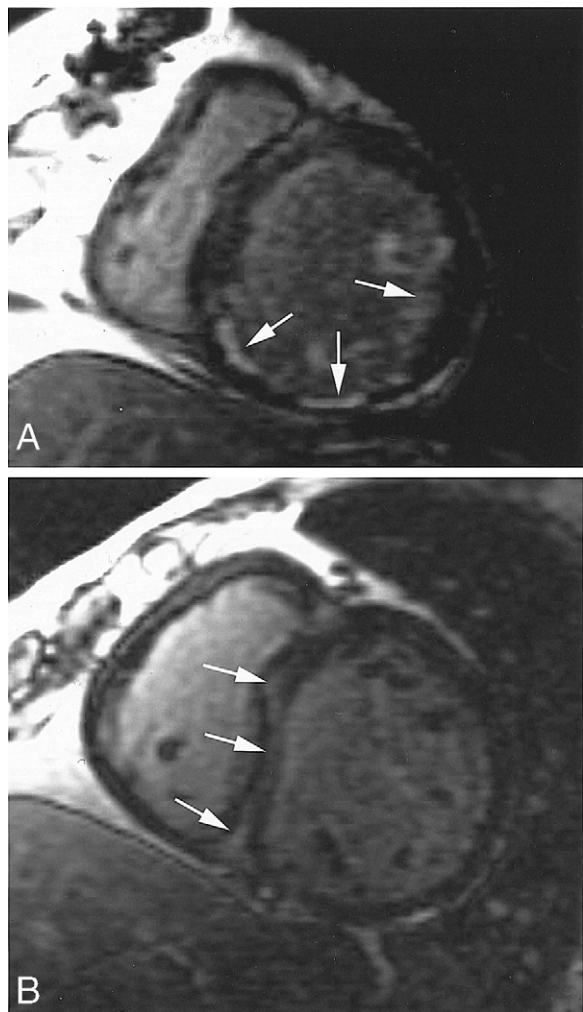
Typical scar patterns seen on delayed-enhancement magnetic resonance imaging in clinical responders with (A) history of myocardial infarction and (B) no history of myocardial infarction (scar indicated by white arrows).
